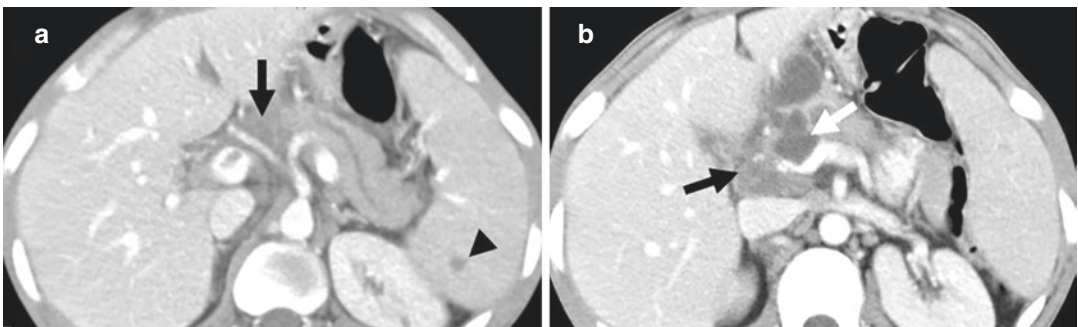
Pancreatic tuberculosis in a 48-year-old immunocompromised man with disseminated tuberculosis that was confirmed on cytology. (a and b) Axial contrast-enhanced CT images show enlarged hypodense peripancreatic lymph nodes (black arrow). There is contiguous
